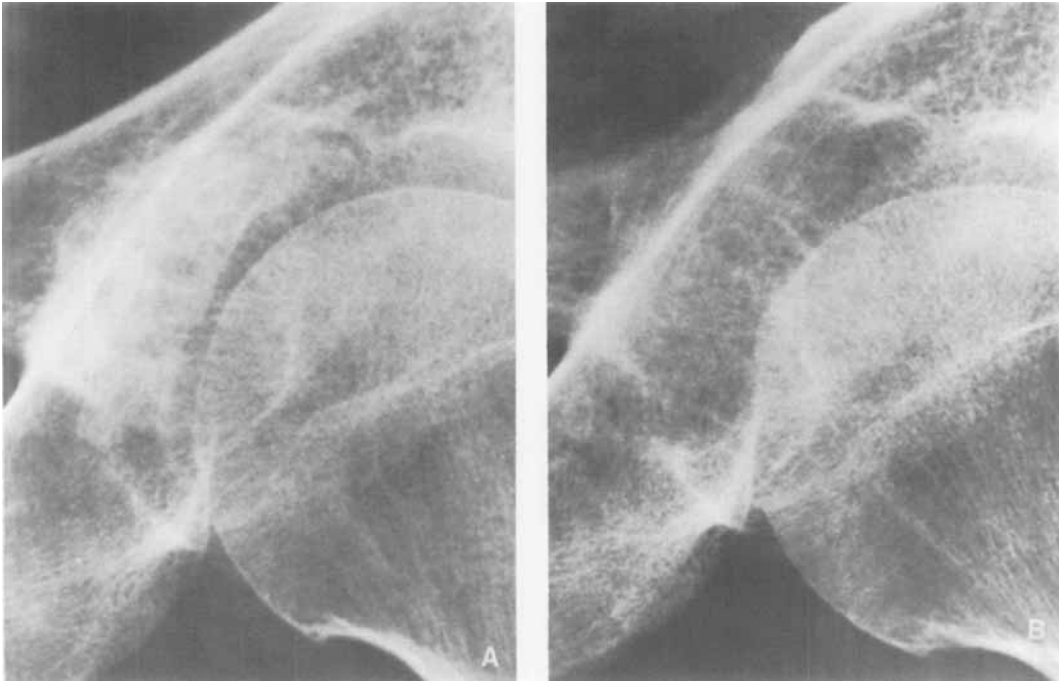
A. Case 2. Preoperative roentgenogram of the left hip joint (Lauenstein position) showing calcified mass in the acetabular fossa.
